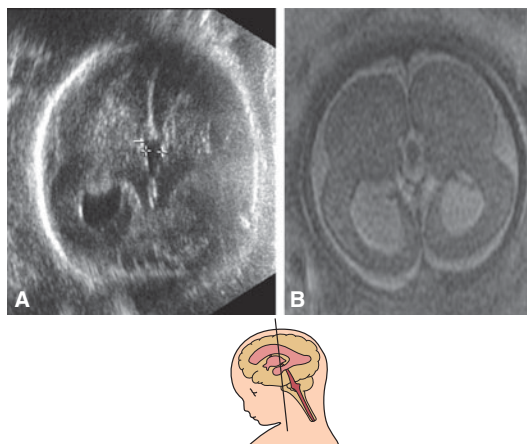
Lissencephaly at 33 postmenstrual weeks. Transabdominal US (A) and MRI (B) axial planes show the lack of sulcation colpocephaly with thick cortex and mild ventriculomegaly. Note the “figure eight” configuration in the MRI.
